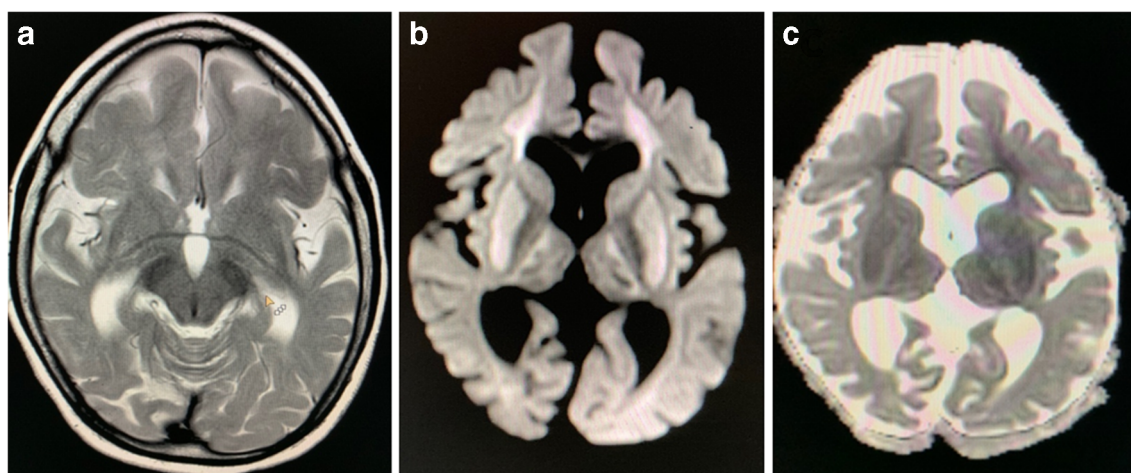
Magnetic resonance imaging of the brain. a Axial T2-weighted section showing generalized atrophy and hypomyelination, b axial diffusion-weighted and c apparent diffusion coefficient showing diffusion restriction in bilateral basal ganglia and periventricular white matter
